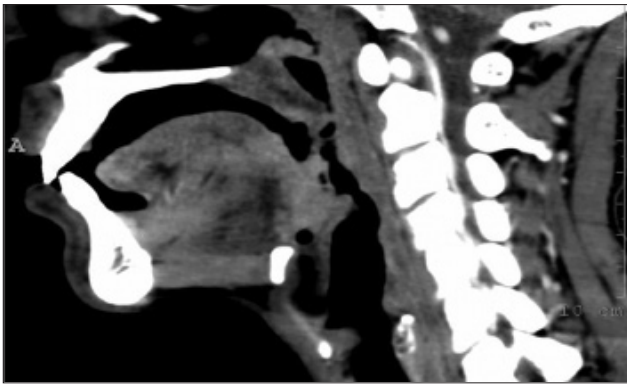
MRI of the airway sagittal section showing the membrane in the oropharynx and no involvement of the airway below
